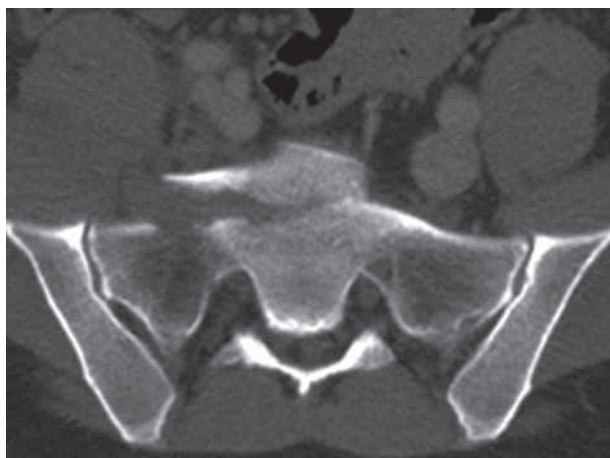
Axial CT image through S1 body showing right-sided ala and promontory fracture.
